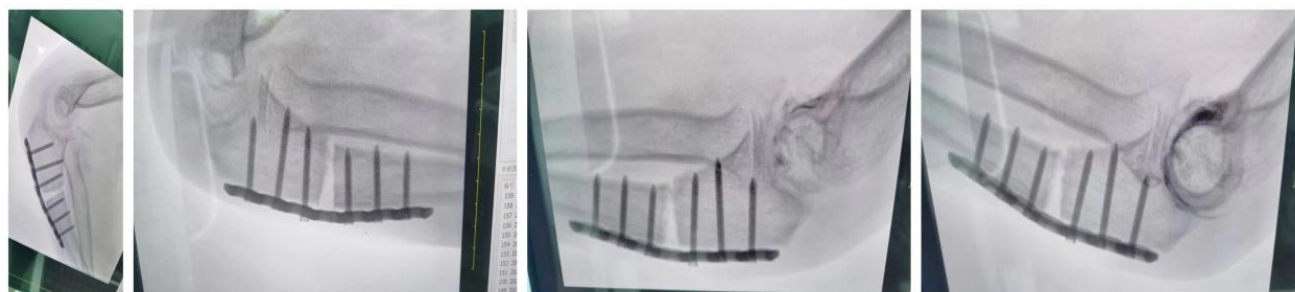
Postoperative radiographic alignment of the humeroulnar joint following proximal ulnar osteotomy.
